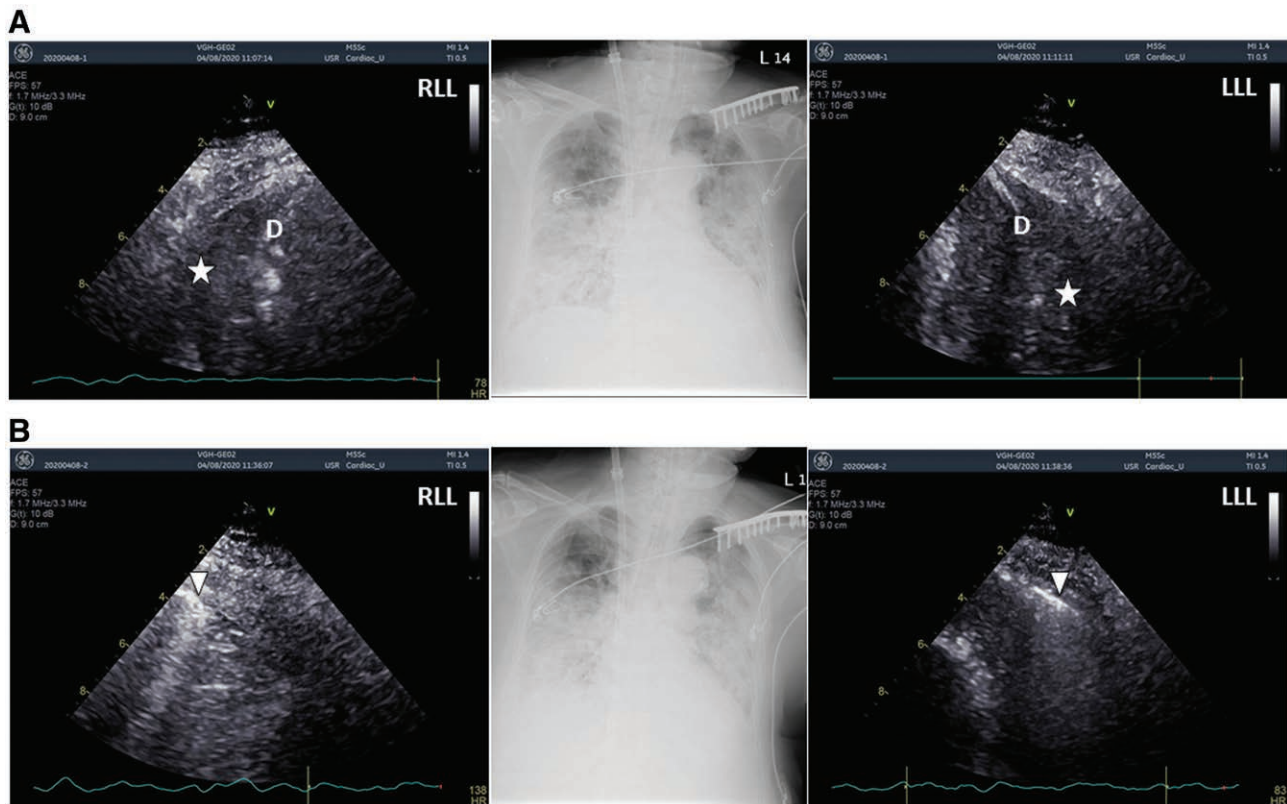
Changes in LUS from (A) before the RM, showing consolidation (white asterisk) in the BLL fields, to (B) immediately after RM, return of lung sliding with B-lines (arrowhead) in the BLL fields. BLL = bilateral lower lung; D = diaphragm; LLL = left lower lung; LUS = lung ultrasound; RLL = right lower lung; RM = recruitment maneuver.
